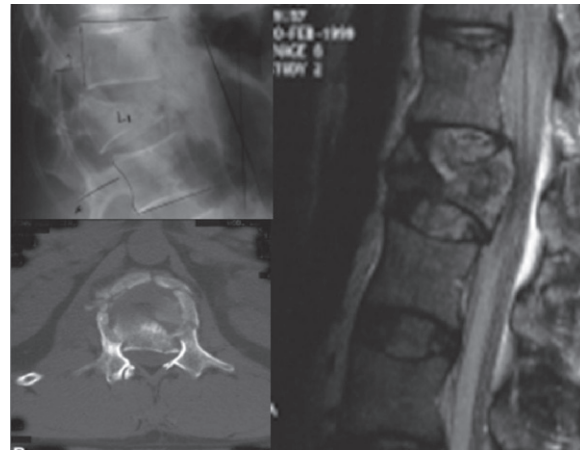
A case of fracture L1, pre op x ray, CT Scan and MRI
